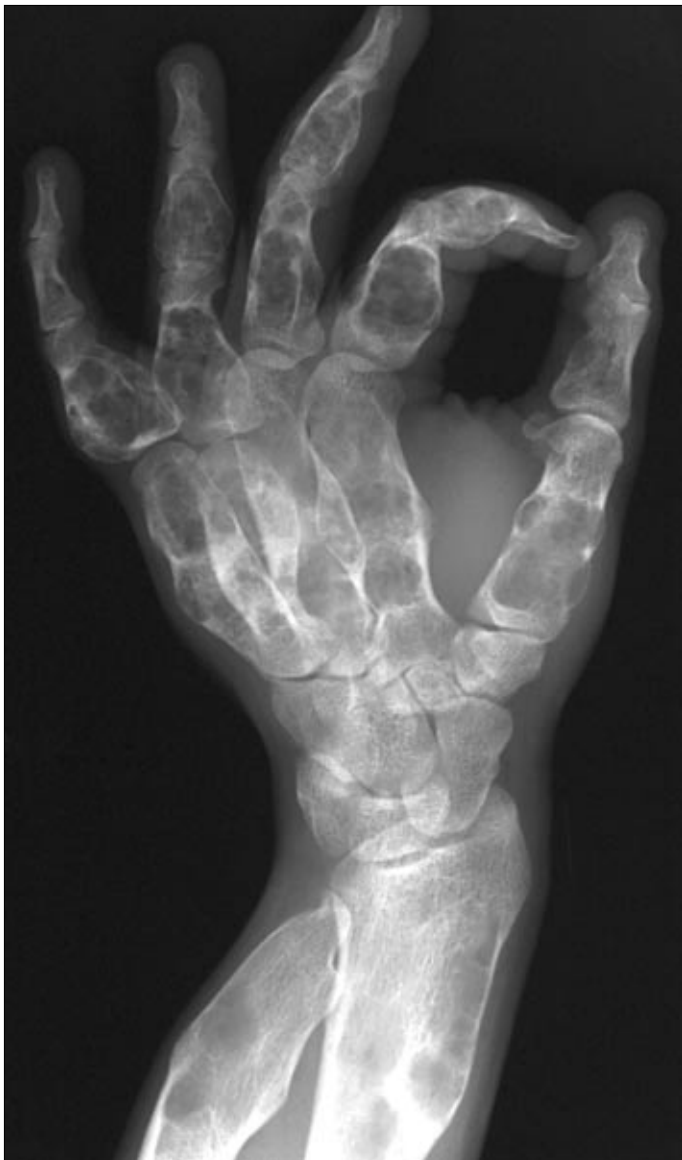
Oblique radiograph of the hand and wrist demonstrates multiple radiolucent, expansile masses of varying shapes in the phalanges, metacarpals, radius, and ulna.
